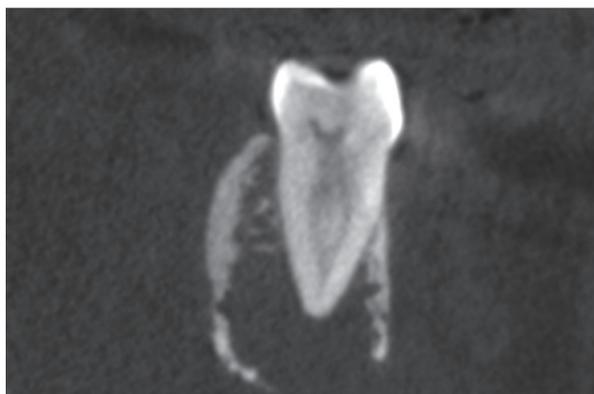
Coronal CBCT section showing a middle distal canal in a mandibular first molar
